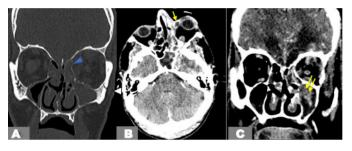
Coronal bone (A), axial (B), and coronal (C) brain windows post-enhanced CT images of the paranasal sinuses and orbits demonstrates mild mucosal thickening of the left maxillary and left ethmoid sinuses (A). Note the subtle bony erosion in the left lamina papyracea (A) (arrow head), hypodense collection along the medial wall of the orbit (B) (arrow) and the maxillary hyperdensity very characteristic of fungal sinusitis (C) (double arrow).
